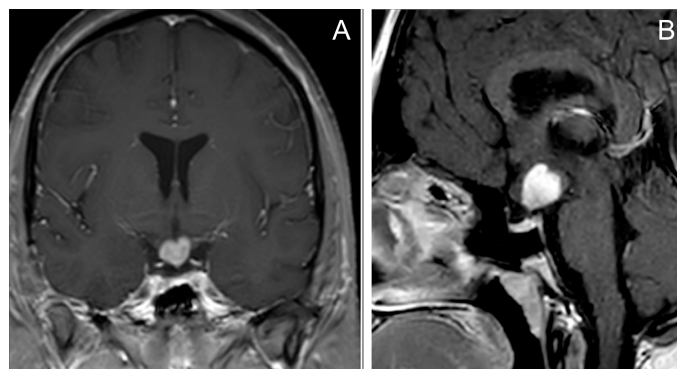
Pituitary magnetic resonance imaging after 3 cycles of chemotherapy treatment (A, coronal slice; B, sagittal slice).
